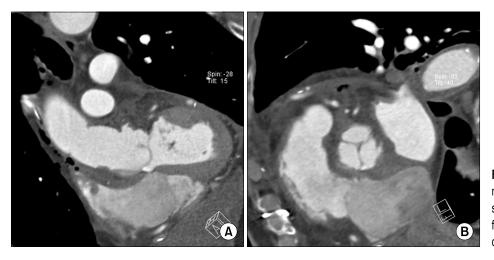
Postoperative computed tomography scan. (A) The size of the sinus of Valsalva was decreased from 58 to 37 mm. (B) The central coaptation defect had disappeared.
